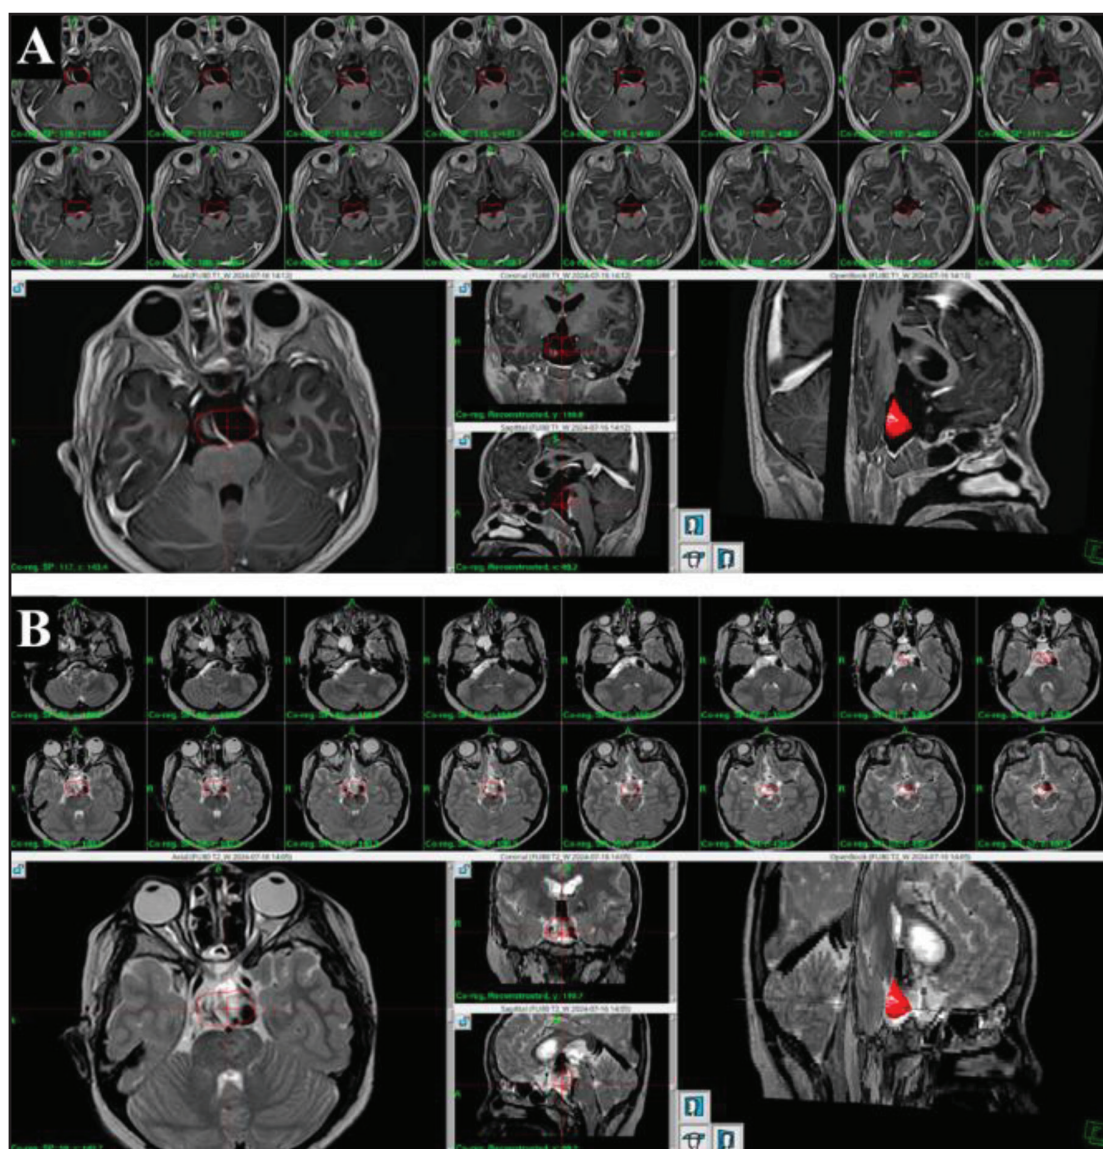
Follow-up MRI of Case 2 at 80 months after GKRS. Axial T1-weighted (A) and T2-weighted (B) images demonstrating a persistent residual lesion measuring 7.790 cm³ with associated cystic and post-treatment changes. Clinical recurrence occurred approximately five years after GKRS despite an initial period of seizure remission.
